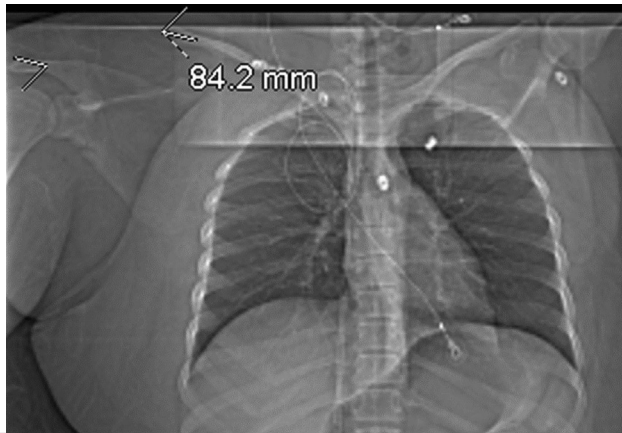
Scout film from computed tomography scan showing an acromioclavicular joint separation of 8.4 cm.
